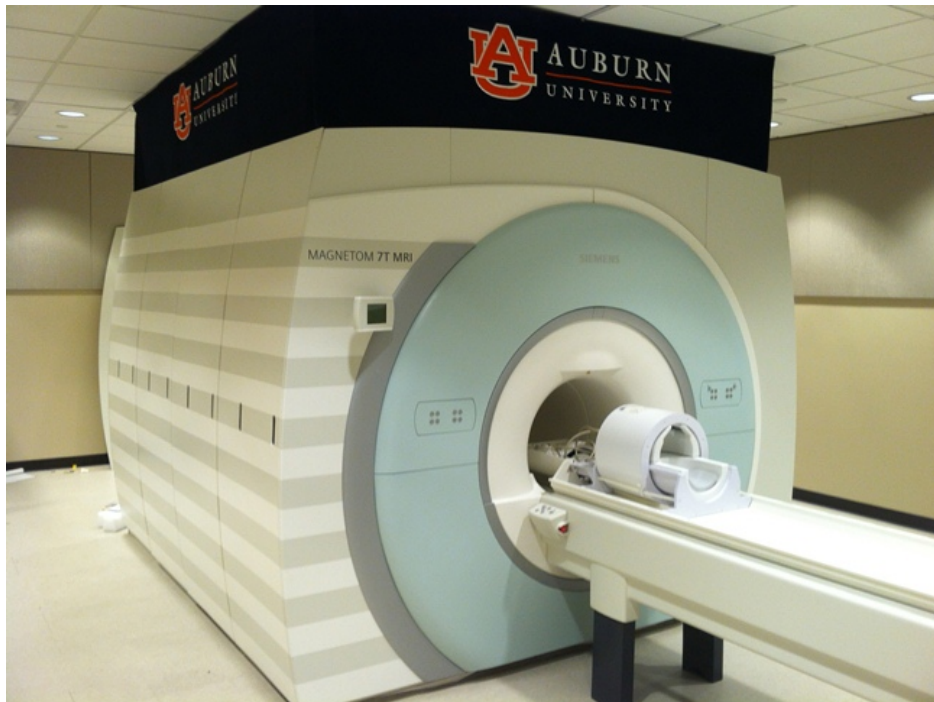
Photo of the 7T MRI Scanner used by Auburn University
